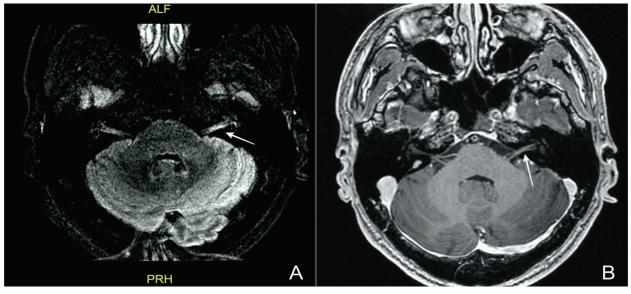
(A) The 3D - FLAIR MRI shows focally high signal intensity in the cisternal segment of the left vestibular nerve (white narrow). (B) The post - contrast T1W MRI shows no enhancement of the left vestibular nerve.
